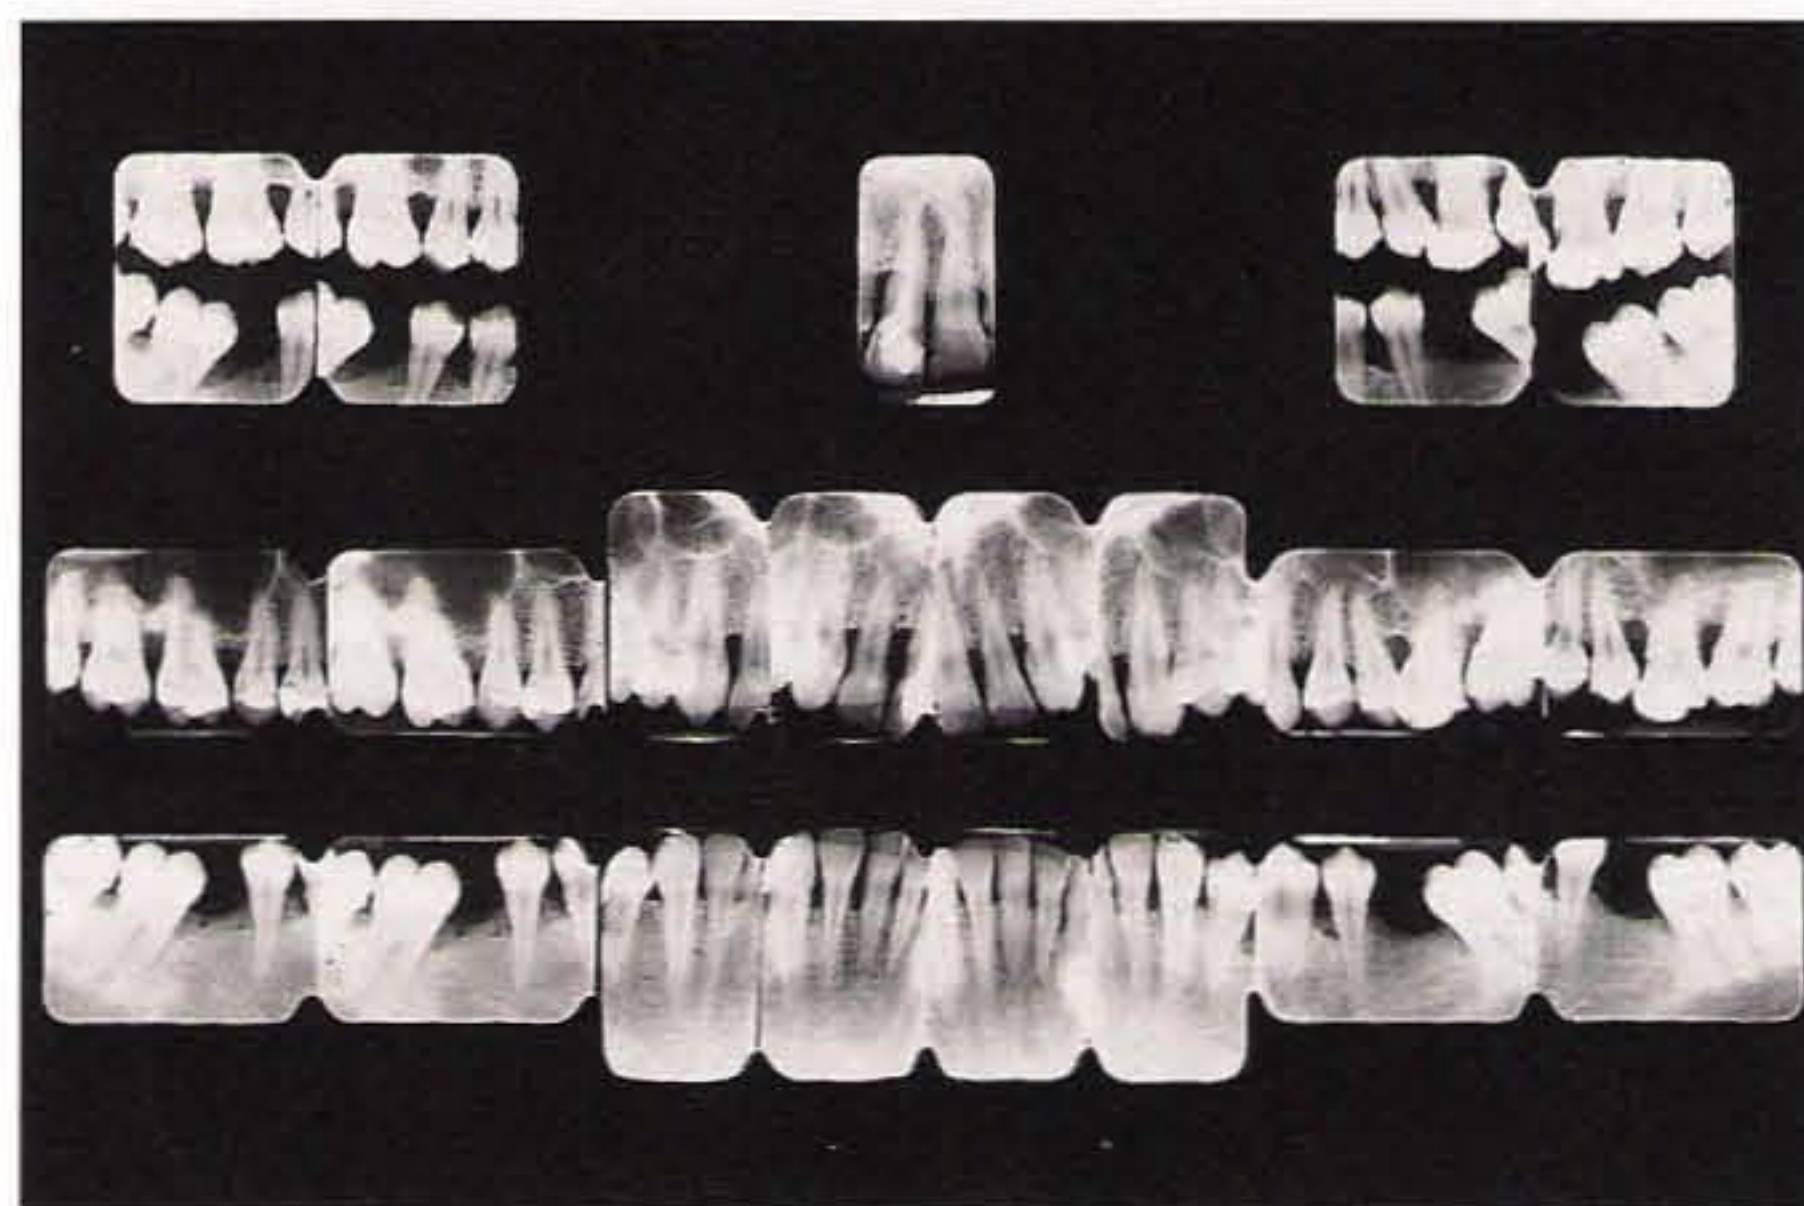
Systematic radiographic examination of patients affected by chronic adult periodontitis.
